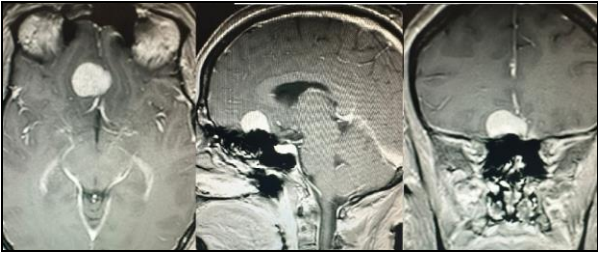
The MRI showing the tumor before surgery.
